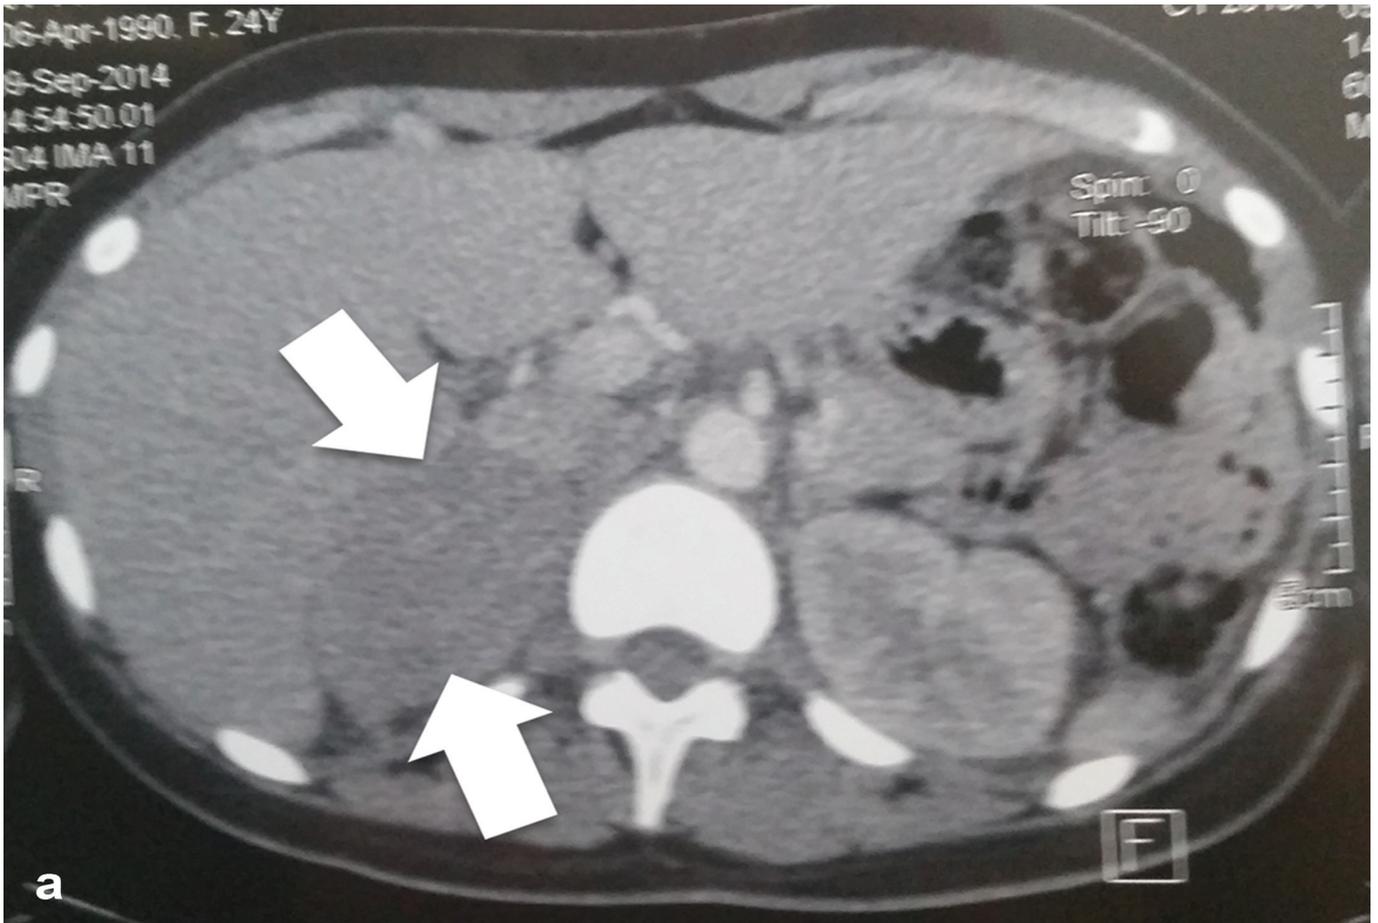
Computed tomography (CT) scan (A) of a 20-year-old female, non-obese, nonsmoker with 1-year history of hypertension and highest BP of 180/120. The adrenal mass measures 7.0 x 5.0 cm. Pathology confirmed PHEO with vascular invasion. Pre-operative 2D-echocardiographic study (B) showed dyskinesia of the septum.
